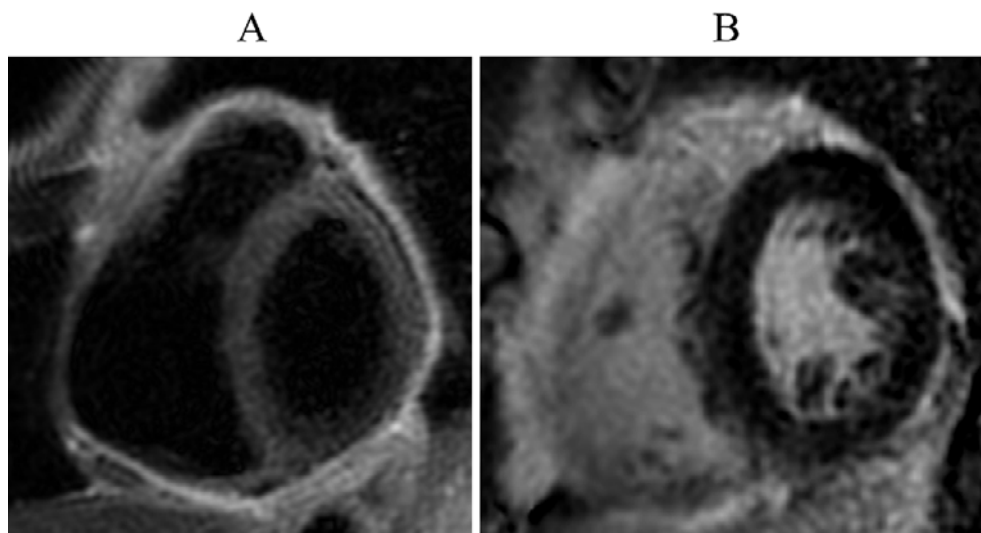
Cardiac magnetic resonance (CMR) imaging 16 days after the initial visit. T2-weighted imaging (A) and late gadolinium enhancement (LGE) (B). There were no significant findings on the LGE or T2-weighted images.
